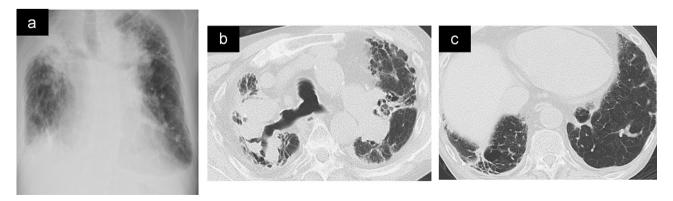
(a) Chest radiograph on admission shows predominant involvement of both upper lung fields and loss of lung volume. (b,c) Chest computed tomography images show conglomerate masses associated with traction bronchiectasis, predominantly in both bilateral upper lobes.
